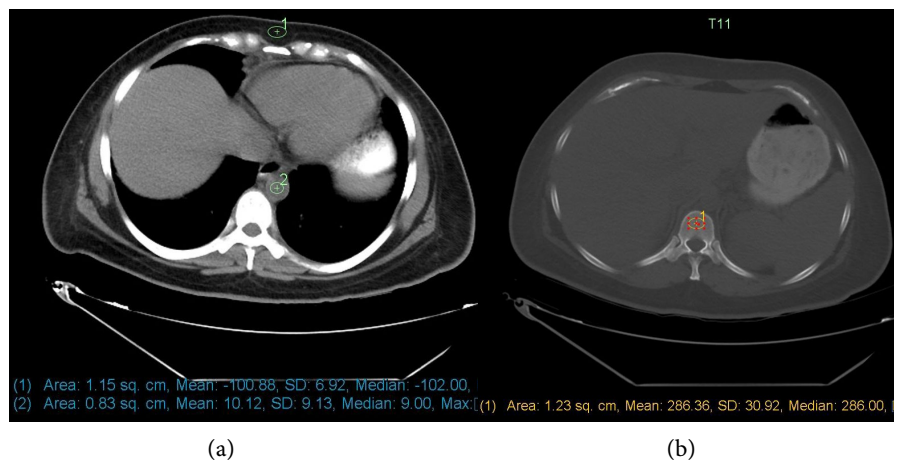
The mean CT values in three regions of interest (ROI) were measured including aortic blood and anterior subcutaneous fat in a soft tissue window for internal calibration, and thoracic vertebrae in the bone window.
